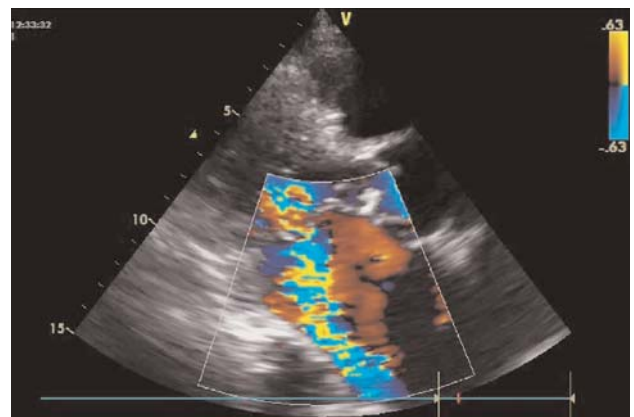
Mitral insufficiency in the color Doppler in the transthoracic echocardiography of the case presented.
